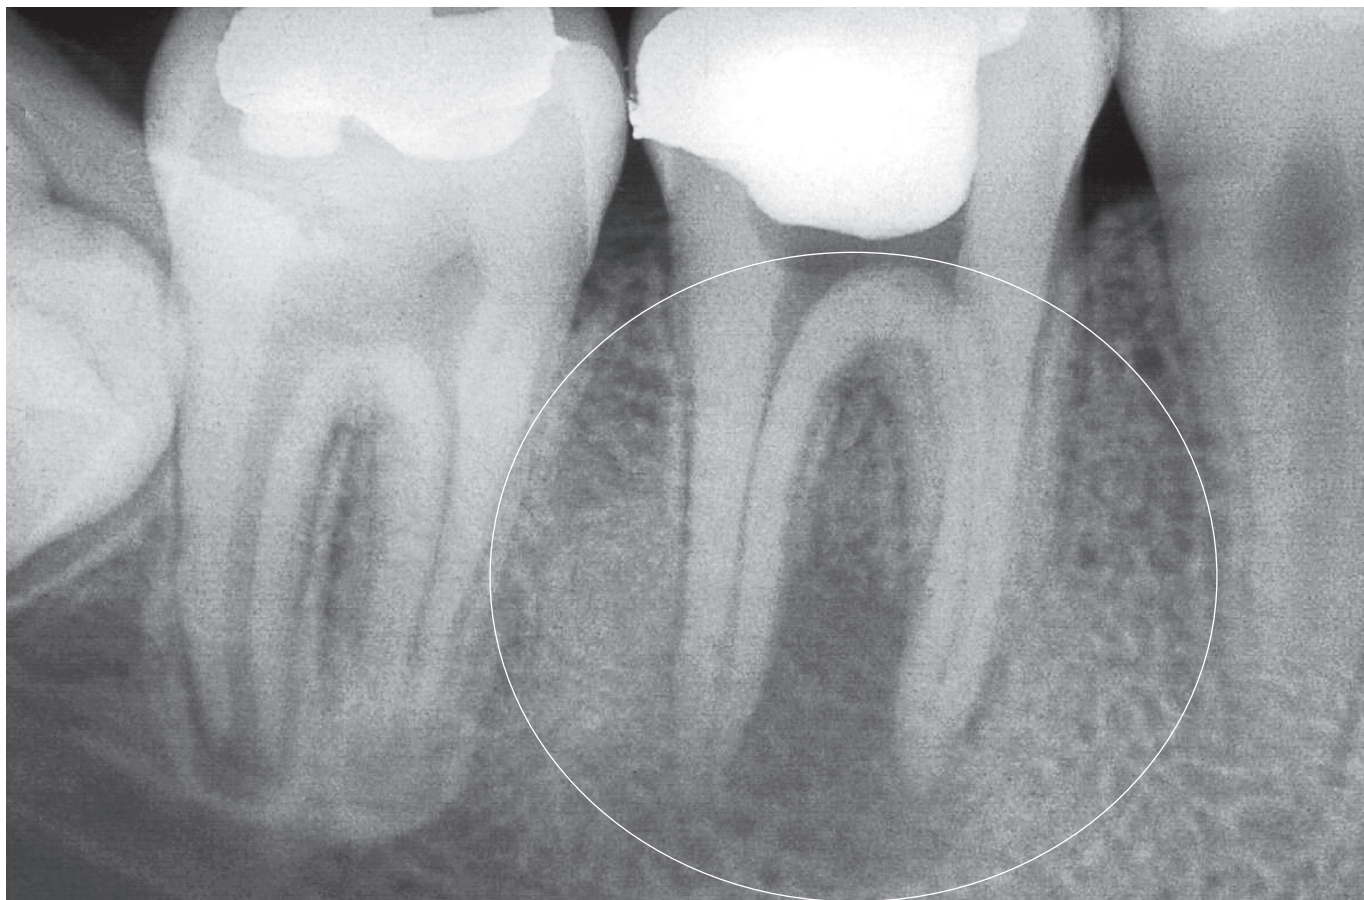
In bone environment, the lesion may be diagnosed as chronic focal rarefying osteitis related to necrotic pulp and chronic inflammatory periapical lesions with imagiologic bone rarefaction predominance with discrete sclerotic peripheral areas. From a clinical and dental point of view, this scenario can be diagnosed as chronic inflammatory periapical lesions compatible with chronic dentoalveolar abscess. The radiolucent areas are more extensive than in the case of Figure 1, and it indicates that the aggressor has a higher pathogenicity, comparatively. Clinically, there was intraoral fistula.
